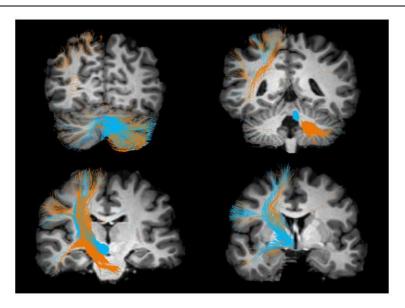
in vivo cerebro-cerebellar loop*. Diffusion tractography can be used to reconstruct the streamlines that connect different cortical areas. Here we show a preliminary graphical representation of the cerebro-cerebellar loop reconstructed in vivo in human starting from the superior and middle cerebellar peduncles as the efferent and afferent points of the cerebellar tracts. Validation of the loop in large populations and using multi modal techniques including MRI and TMS is currently under investigation. (Courtesy of Fulvia Palesi and Andrea De Rinaldis, UNIPV, Italy)
